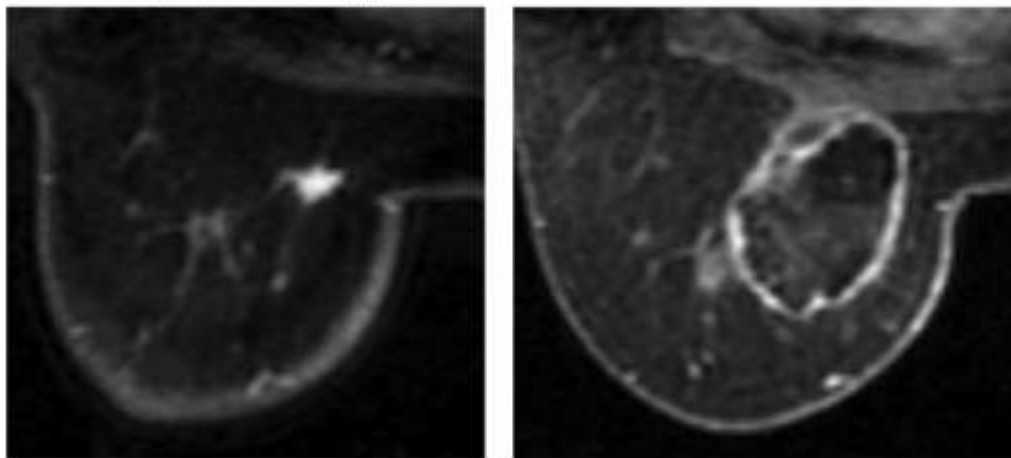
The larger wound vanished and a particular peripheral growth was seen on MR imaging after RFA.
